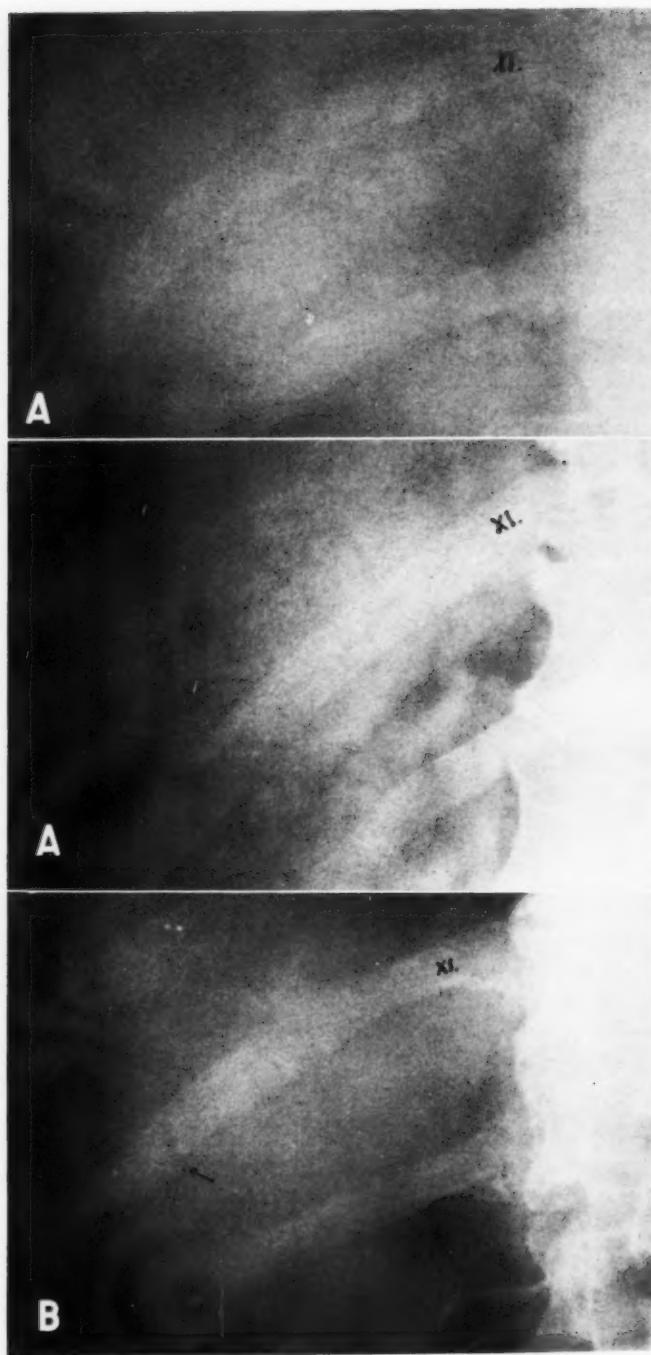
A. Anteroposterior and oblique roentgenograms, May 8, 1943. No definite fracture is seen. B. Anteroposterior roentgenogram, May 28, 1943. The fracture gap of the right 11th rib is indicated by the arrow.
